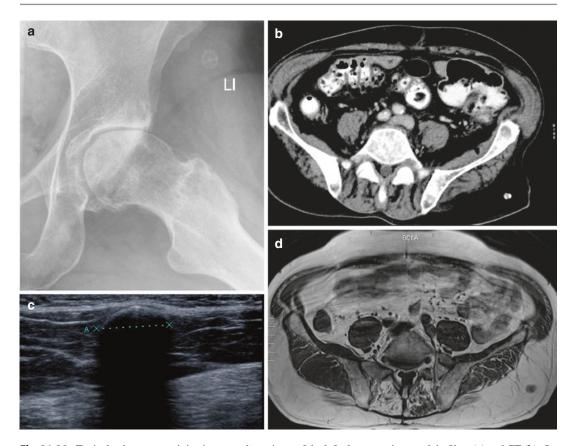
Typical subcutaneous injection granuloma in the left gluteal area: (a) plain radiograph of the left hip, (b) CT, (c) ultrasound, and (d) axial turbo spin echo T2-weighted MR image. A round, well-defined ringlike calcification lesion is seen within the subcutaneous tissue
